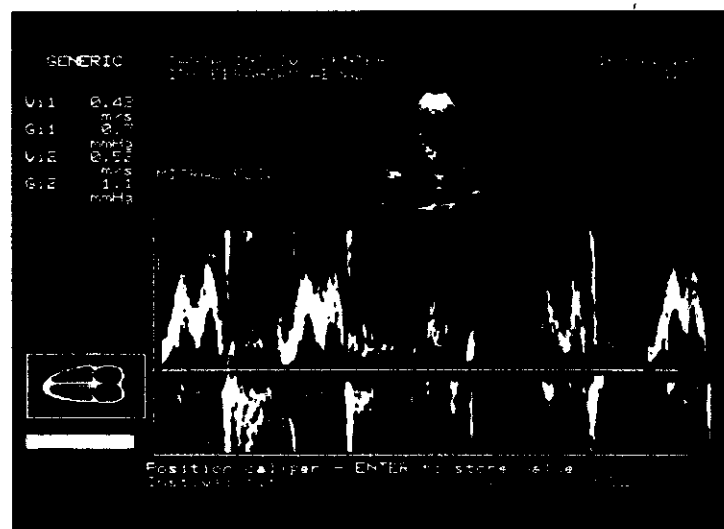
Mitral flow by pulsed Doppler. It shows reversed E/A ratio (diastolic dysfunction) and moderate mitral regurgite.
